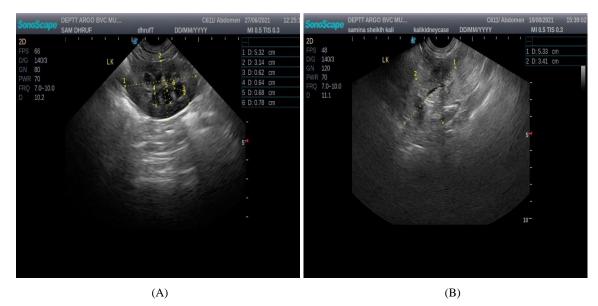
Ultrasonographic Examination of Left Kidney in Apparently Healthy Control Group (A) and Kidney Disease Group Showing Loss of Architectural Details and Poor Differentiation of Corticomedullary Junction (B)
